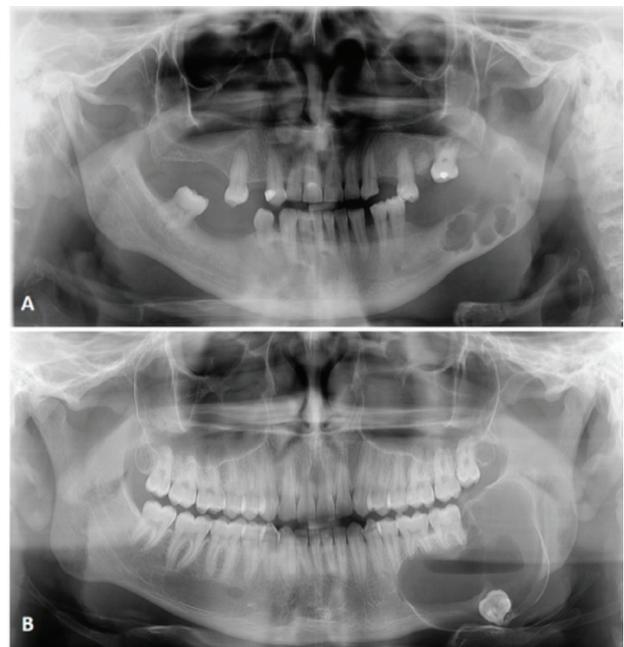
Panoramic radiographs: A- Case 1, multilocular radiolucent image; B- Case 2, well-defined unilocular corticated radiolucent image.
